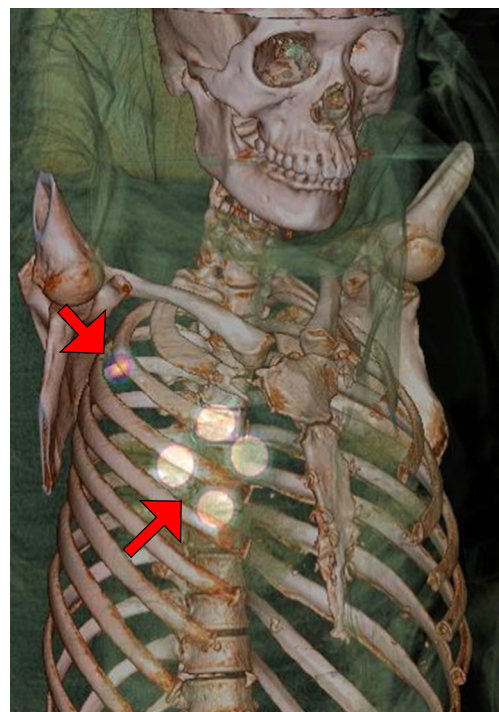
A representative hybrid lymphoscintigraphy image with breast cancer. This 3D image shows sites of SLNs and the periareolar injection area
